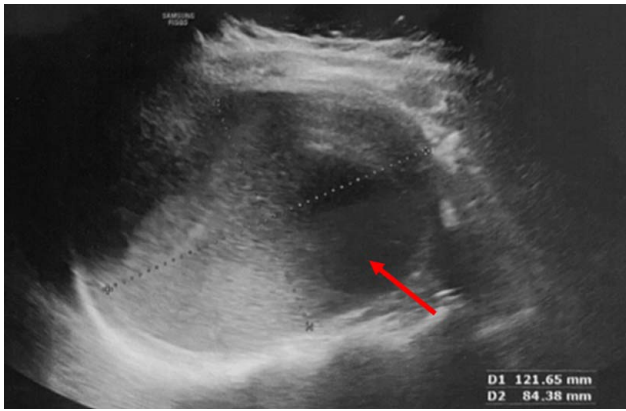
Abdominal ultrasound found a large splenic unilocular cystic mass of 12×9 cm, oval-shaped, with clear and regular borders, a thin wall with fine hyperechoic speckles (red arrow).
